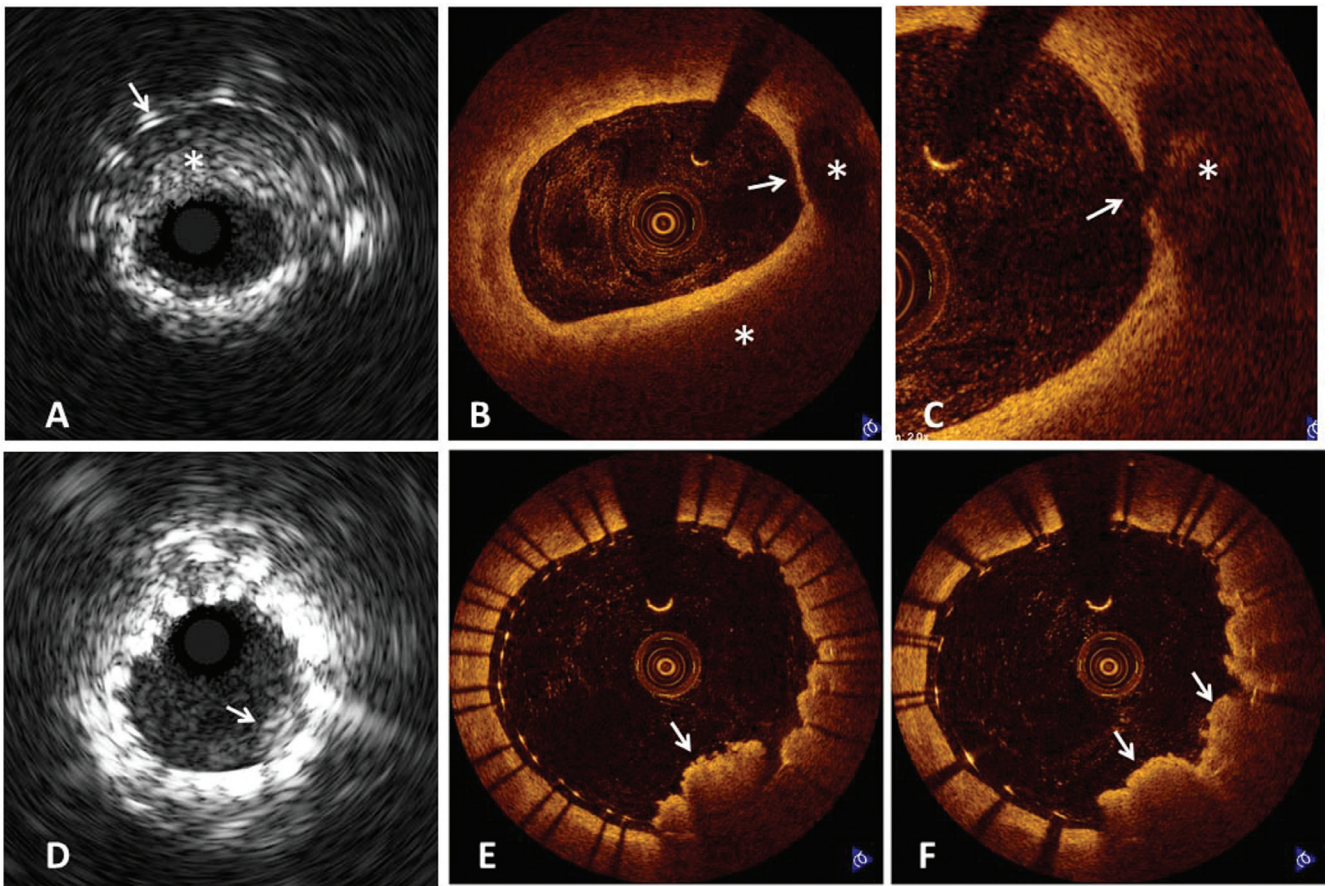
Findings of neointima inside the previous bare-metal stent. A: Gray-scale intravascular ultrasound (IVUS) imaging showing neointimal thickness (asterisk) inside the previous stent (arrow). B: Optical coherence tomography (OCT) imaging demonstrating heterogeneous intima and thin fibrous cap (arrow) with lipid-rich component (asterisk). C: Another section of OCT imaging revealing fibrous cap disruption (arrow) with lipid component (asterisk). Findings of inside the additional stent. D: Gray-scale IVUS imaging showing suspicious tissue protrusion (arrow) inside the additional stent. E, F: OCT imaging clearly demonstrating tissue protrusion (arrow) from the spaces between stent struts.
